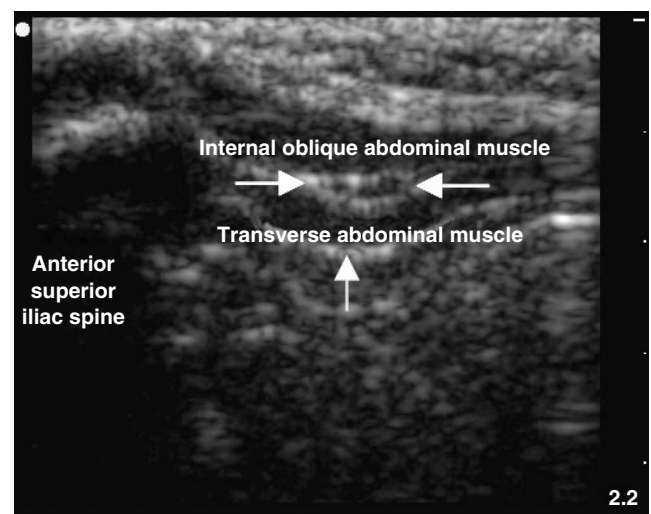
Cross-sectional ultrasonographic view of the ilioinguinal nerve (indicated by the white arrows) between the internal oblique and transverse abdominal muscles. The peritoneum (indicated by the grey arrow) is at a distance of 3 mm in this 10-kg child.
